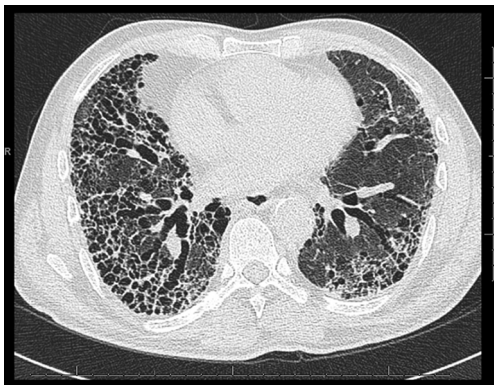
An HRCT of the lungs showing the classical UIP pattern: honeycomb transformation, the sub-pleural distribution and traction bronchiectasis can be discerned. HRCT, high resolution computed tomography; UIP, usual interstitial pneumonia.
